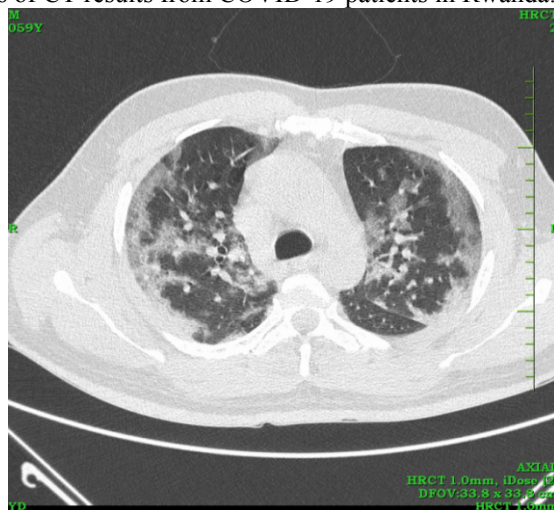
Axial non-enhanced HRCT with GGO.
